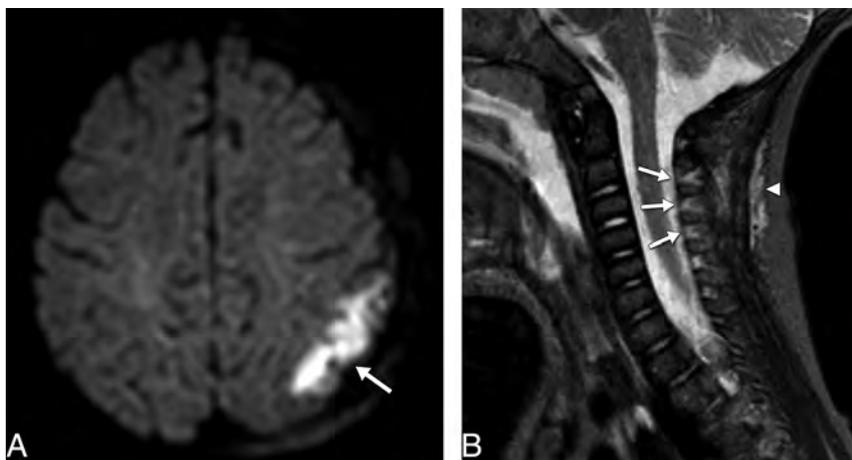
Seven-month-old patient. A, Axial DWI shows focal restricted diffusion in the left parietal lobe (arrow). B, Sagittal midline STIR image demonstrates interspinous ligamentous injury (arrows) and injury to the nuchal ligament (arrowhead).
